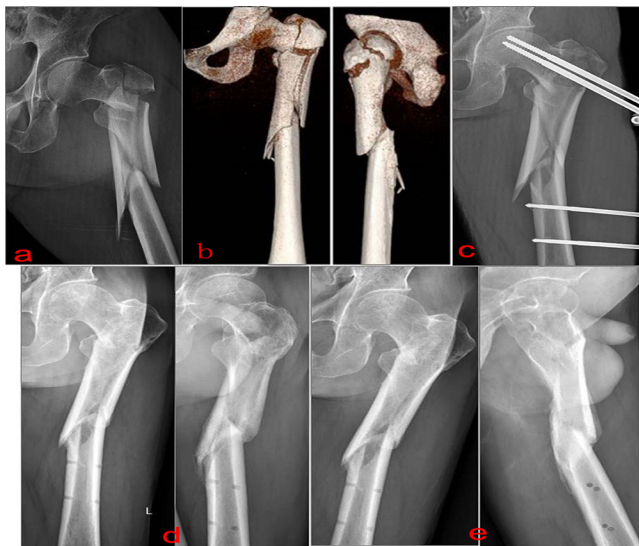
A 77-year-old male, AO type 31 A3.3. a. Preoperative anteroposterior X-ray; b. Preoperative 3-D CT scan; c. Immediate postoperative anteroposterior X-Ray; d.6 months post-operative anteroposterior and oblique X-ray, patient full weight bearing;
